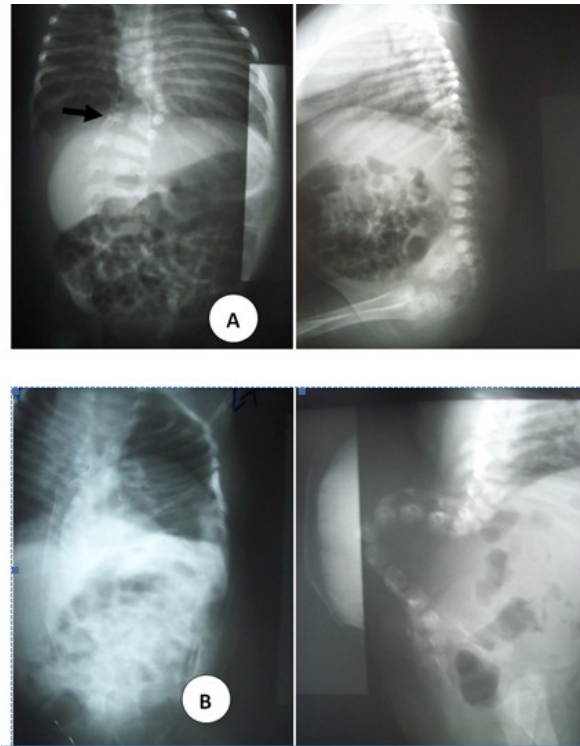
A: anteroposterior and lateral radiographs of 22 days aged female with lumbo- sacral spina bifida showing a segmented hemivertebra in T12 (*black arrow*). Scoliosis is already developed. B: Anteroposterior and lateral radiographs of spine for 28 days age infant with large lumbar myelomeningocele, associated with kyphosis and scoliosis.
